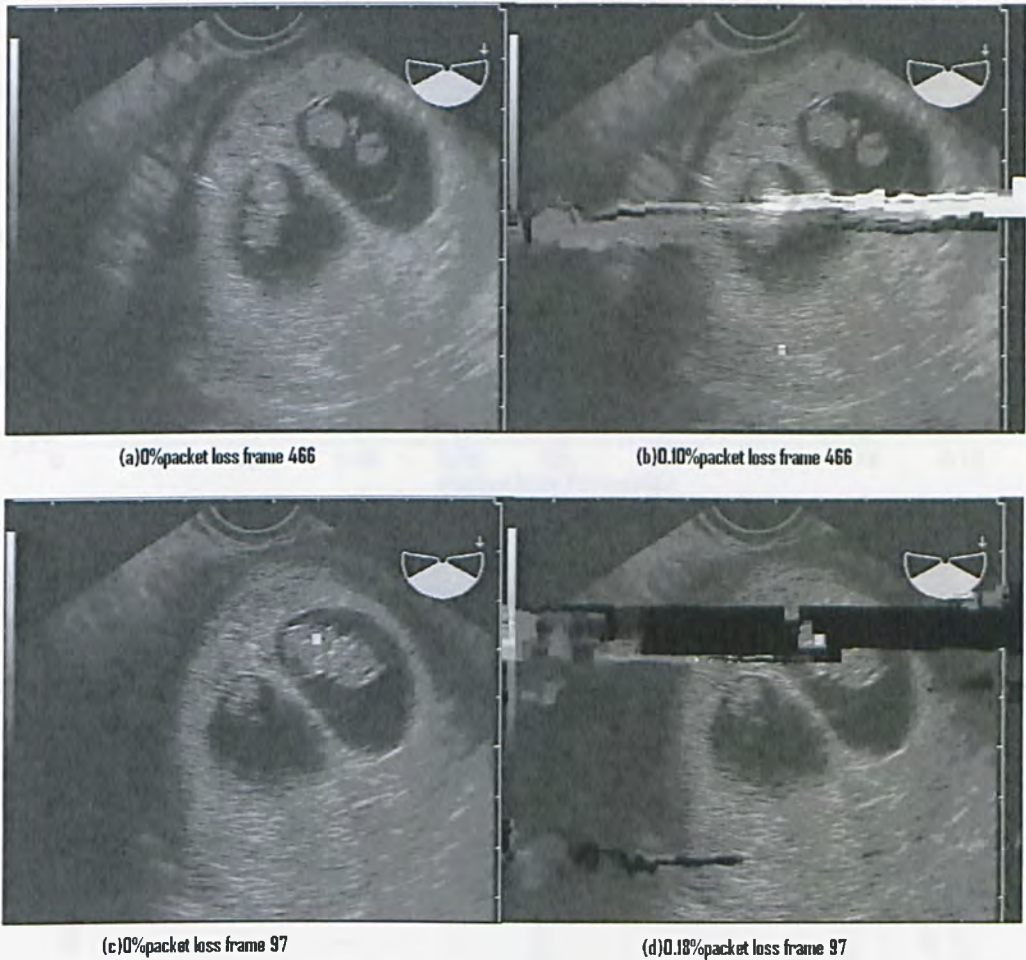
Experimental test ultrasound images (a), (c) Packet loss =0.00% Average PSNR=38.61dB Average SSIM=0.966 Average MSE =9.43 (b) Packet loss =0.10% Average PSNR=35.37dB Average SSIM = 0.944 Average MSE =20.00 (d) Packet loss =0.18% Average PSNR=34.97dB Average SSIM = 0.941.
